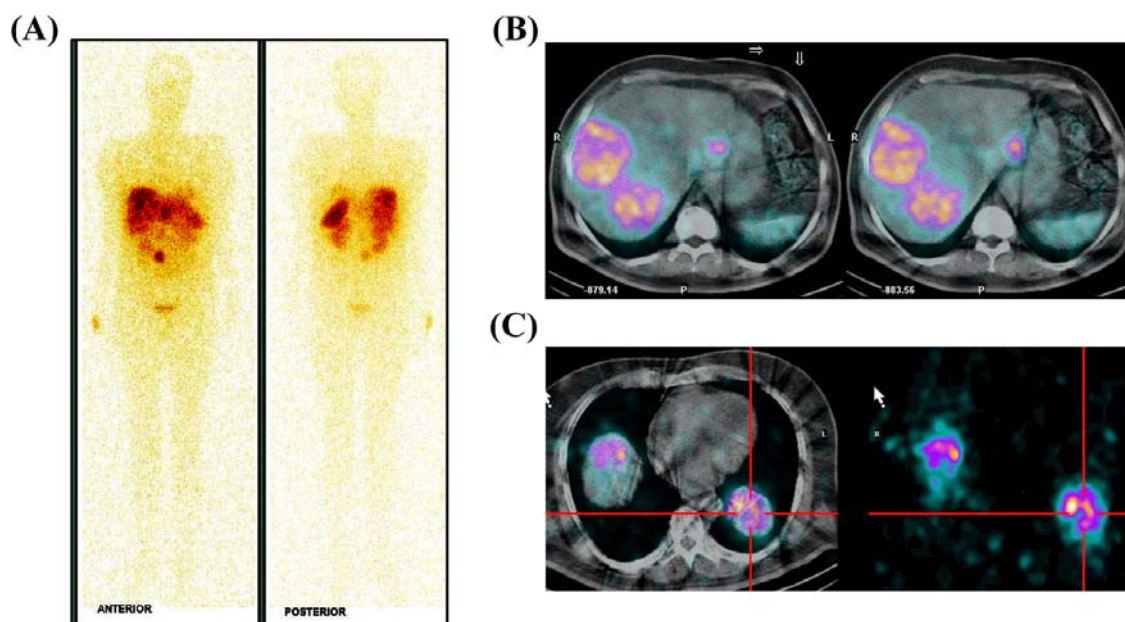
Whole-body scintigraphic images of a patient recorded after administration of 10 mCi (370 MBq) of ^{177}Lu -DOTA-TATE. SPECT-CT images of (B) liver and (C) lung lesions of the same patient.
